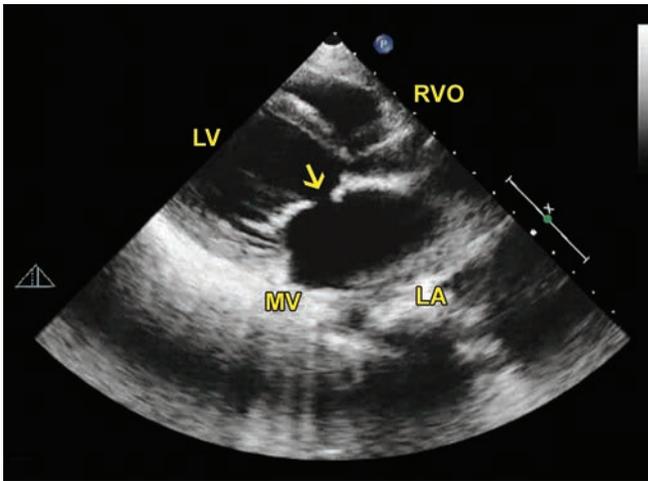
Parasternal long axis view. Arrow points to a perforation in the anterior MV leaflet. LA is dilated.
